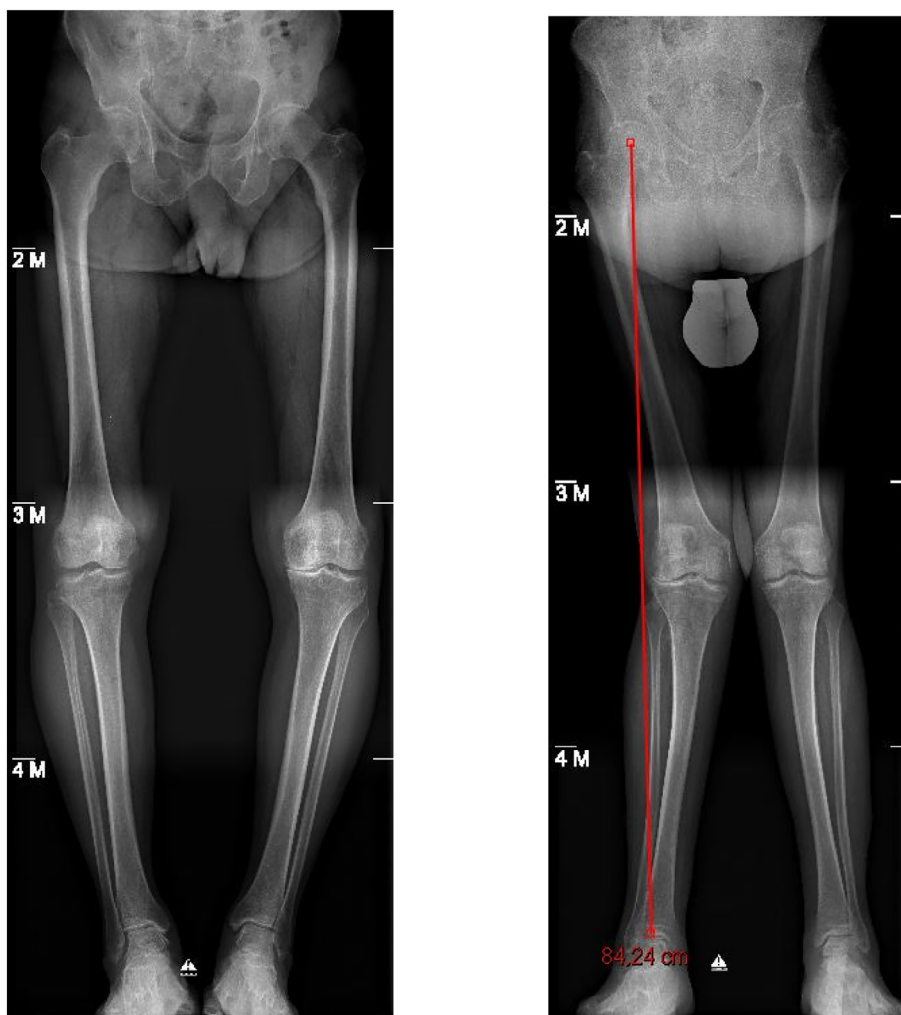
X-Ray images of lower limbs with load preoperatively.
